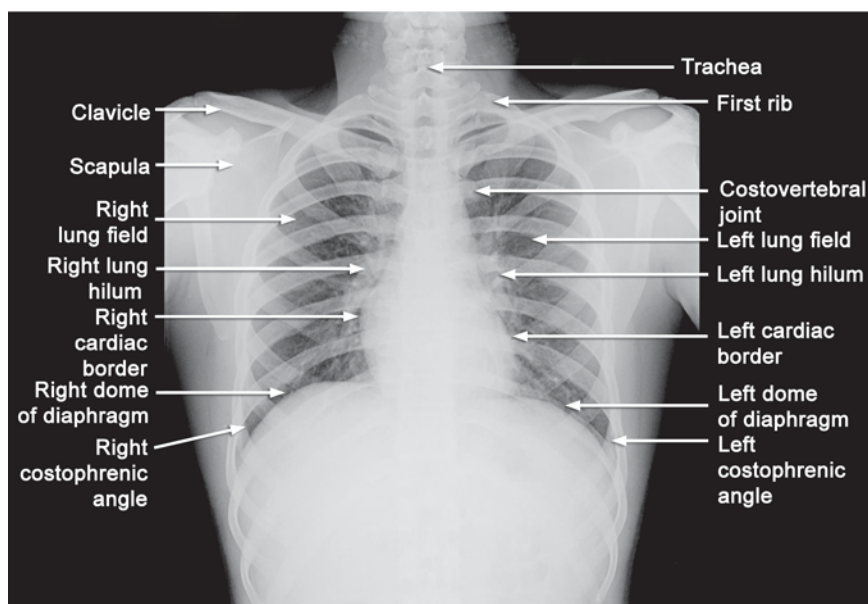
X-ray chest PA view
